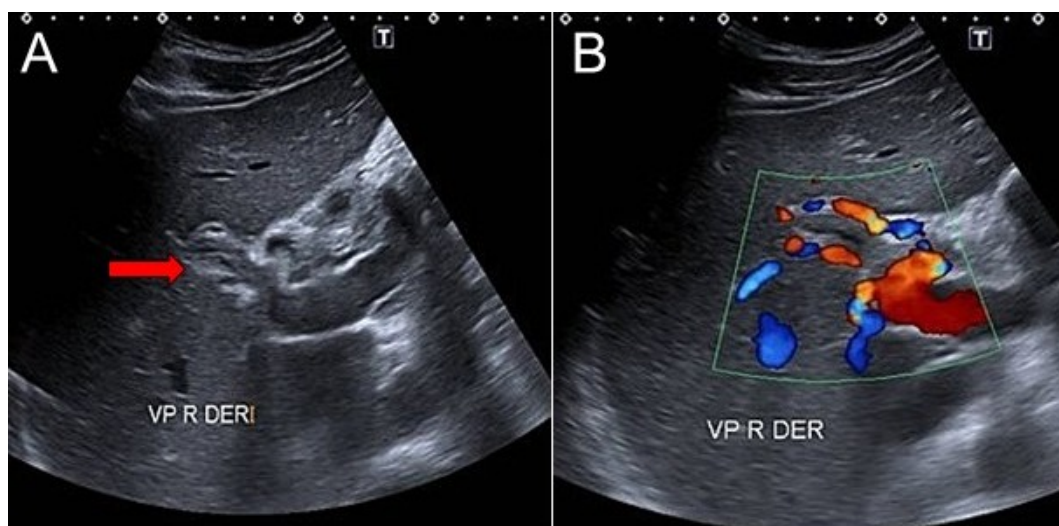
Hepatic Doppler US. A. Right portal vein branch containing echogenic material within the lumen (arrow). B. Color Doppler demonstrating absence of portal venous flow, confirming portal vein thrombosis.
